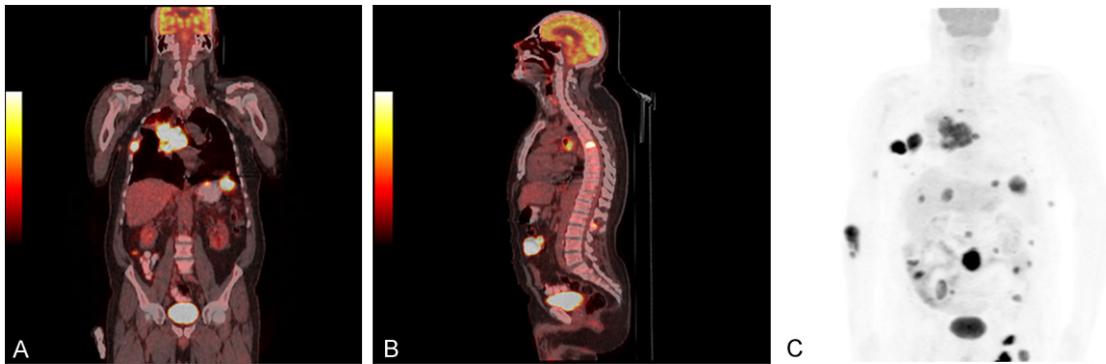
Multiple metastasis in a 61 year old non-small cell lung cancer diagnosed male patient (patient number 14): A: Coronal PET-CT image. B: Sagittal PET-CT image. C: PET image.
